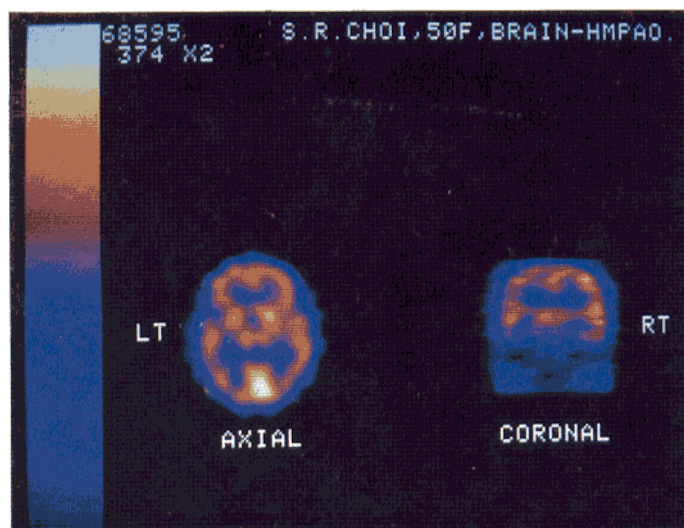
HM-PAO brain SPECT image of patient 4 demonstrated symmetric cortical rCP.
